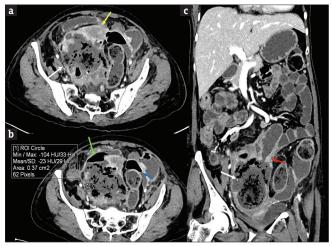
CECT of the abdomen. (a and b) Axial images show a large irregular, predominantly cystic mass with peripheral heterogeneously enhancing solid areas in the right adnexal region (white arrow) posterior to the uterus (yellow arrow). The mass shows areas of fat attenuation (indicated in ROI in B) along with multiple areas of mottled air foci, air-fluid level (green arrow), and extraluminal air (blue arrow), (c) The coronal oblique image shows foci of calcification (white arrow) within the mass. It depicts a direct fistulous communication between an ileal loop and the dermoid cyst (ileo-dermoid fistula - red arrow) with proximally dilated small bowel loops. CECT: Contrast-enhanced computed tomography, ROI: Region of interest
